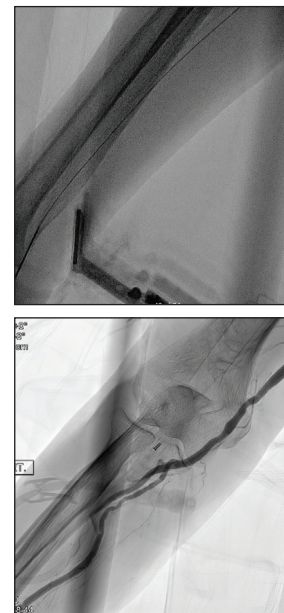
Ultrasound-guided access of the radial artery access and angiogram.
